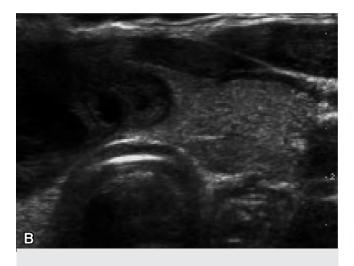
Ultrasound of a hyperplastic colloid nodule in the isthmus and right lobe. A, Transverse, 14×23 mm. B, Transverse. C, Longitudinal, sagittal diameter: 27 mm.
